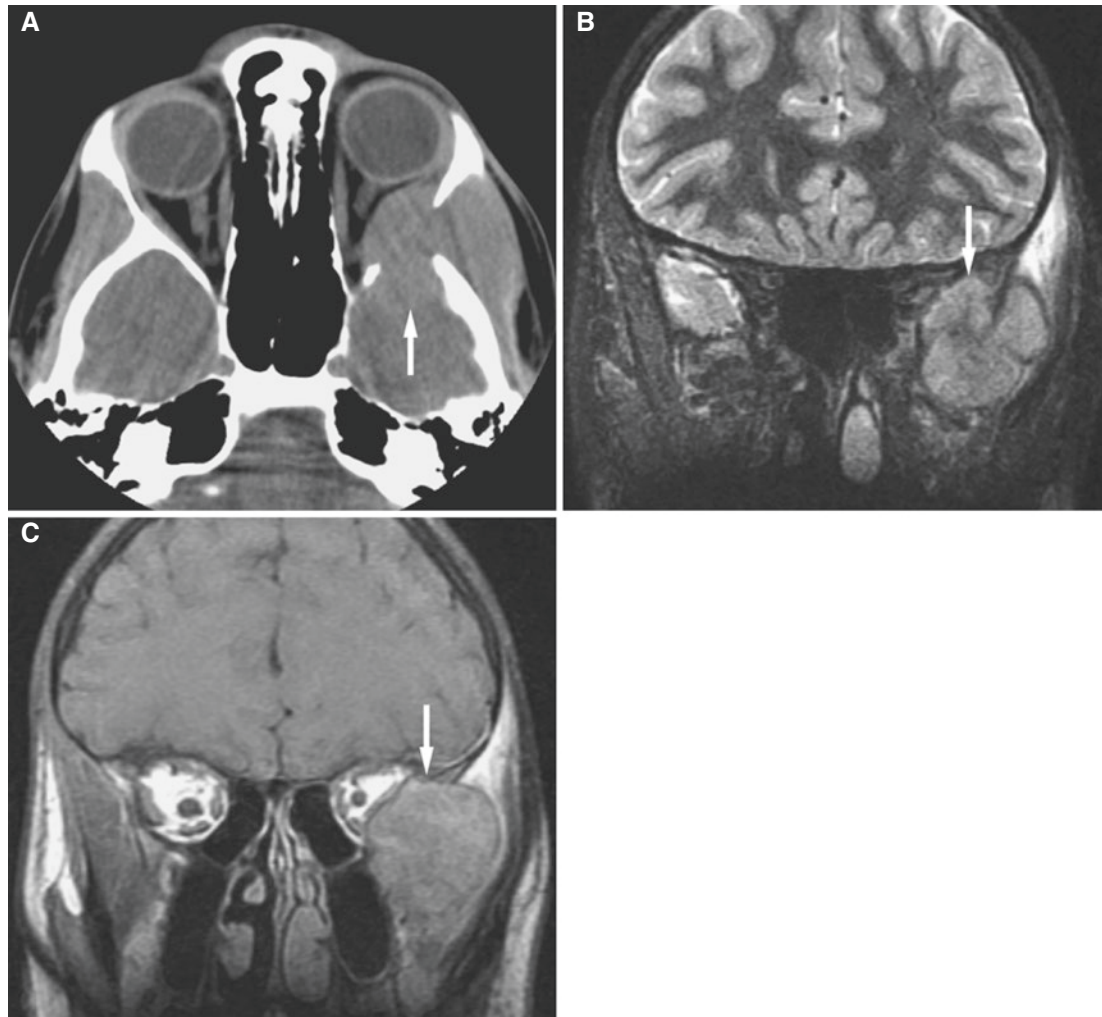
Langerhans cell histiocytosis of orbit; 14-year-old male with two weeks of headache, now with periorbital swelling. Clinical question of infection or mass. (A) Axial CT image shows homogeneous soft-tissue mass (arrow) without calcification in retro-orbital and greater sphenoid space. There is a punched-out bony lesion involving
